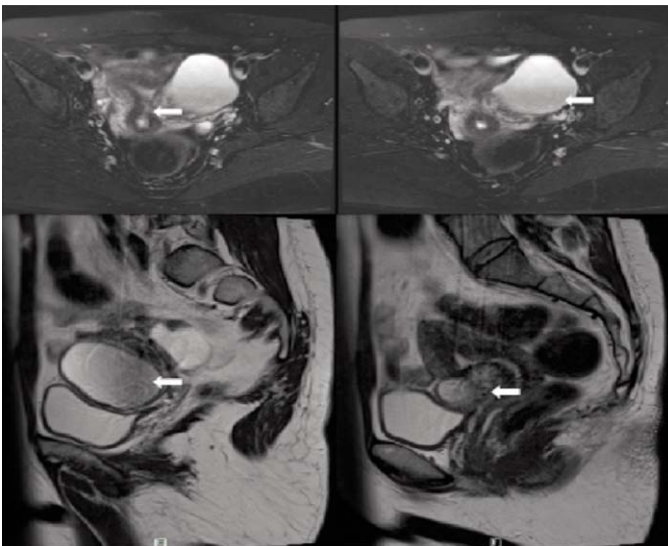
Magnetic resonance imaging image.
